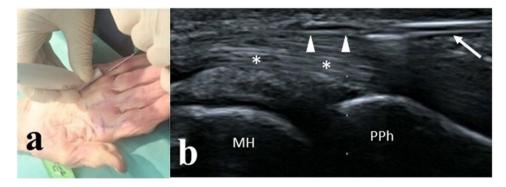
Needle technique. (a) Inserting a 21 G needle under ultrasound guidance with a stick probe. (b) Ultrasound image identifying the needle penetrating the deepest most distal part of the A1 pulley. MH: metacarpal head. PPh: proximal phalanx. The arrowheads indicate the A1 pulley. The arrow indicates the needle. The asterisks indicate the flexor tendons
